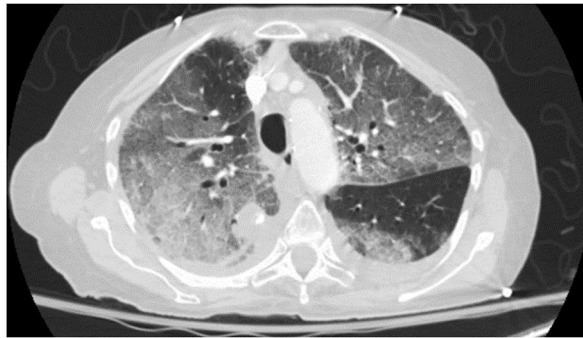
CT of the chest showing diffuse bilateral ground glass opacities.
